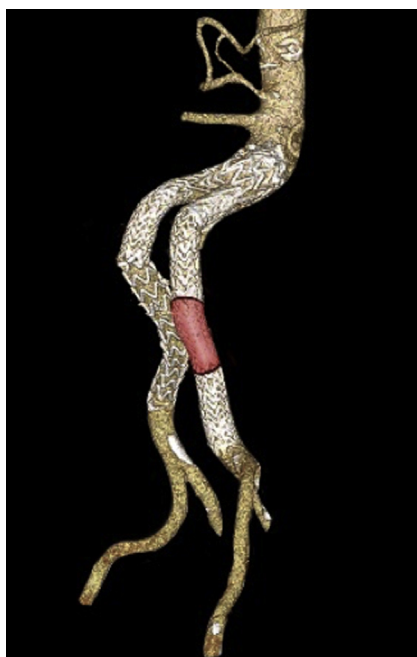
Postoperative computed tomography scan reconstruction demonstrating endograft with a Dacron interposition graft.
